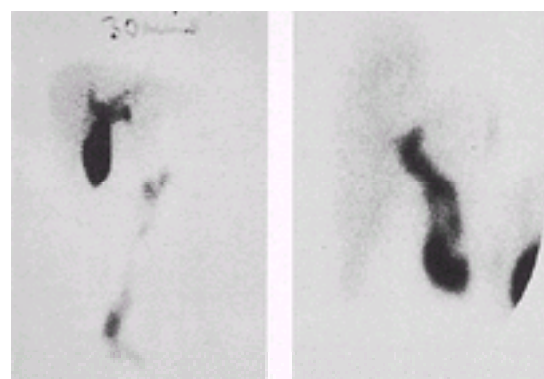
Technetium-99m HIDA cholecystoscintigraphy in a normal person 30 min postinjection (left) and in a patient with acute cholecystitis (right) 60 min postinjection. The gallbladder is clearly visible early in the study in the normal situation but not even at 1 h in cholecystitis.
